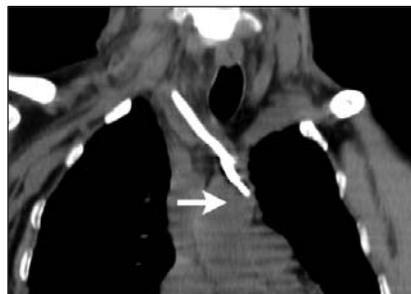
Computed tomography scan, coronal view, of the neck and the thorax showing the catheter passing through the superior mediastinum into the ascending arch of the aorta (arrow).
